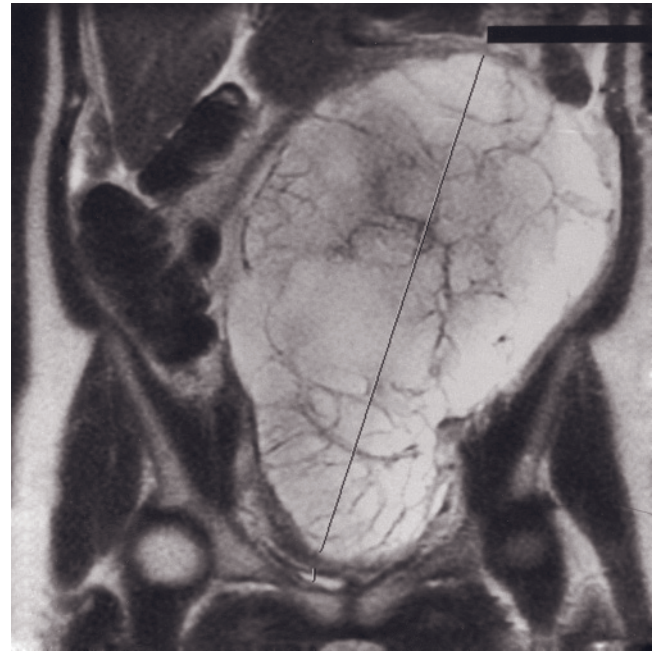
Large subserosal leiomyoma mimics an ovarian mass in a pregnant patient. Coronal (a) and transverse (b) T2-weighted SS-ETSE, fat-suppressed T2-weighted SS-ETSE (c), and T1-weighted gradient-echo (d) images show a large mass arising from the uterus (arrow). Although signal intensity on T2-weighted images (a–c) is higher than seen in a typical fibroid, the myometrium is splayed (arrowheads) around the mass, indicating uterine origin. A fat plane is not observed between the mass and the uterus on the T1-weighted image (d).
